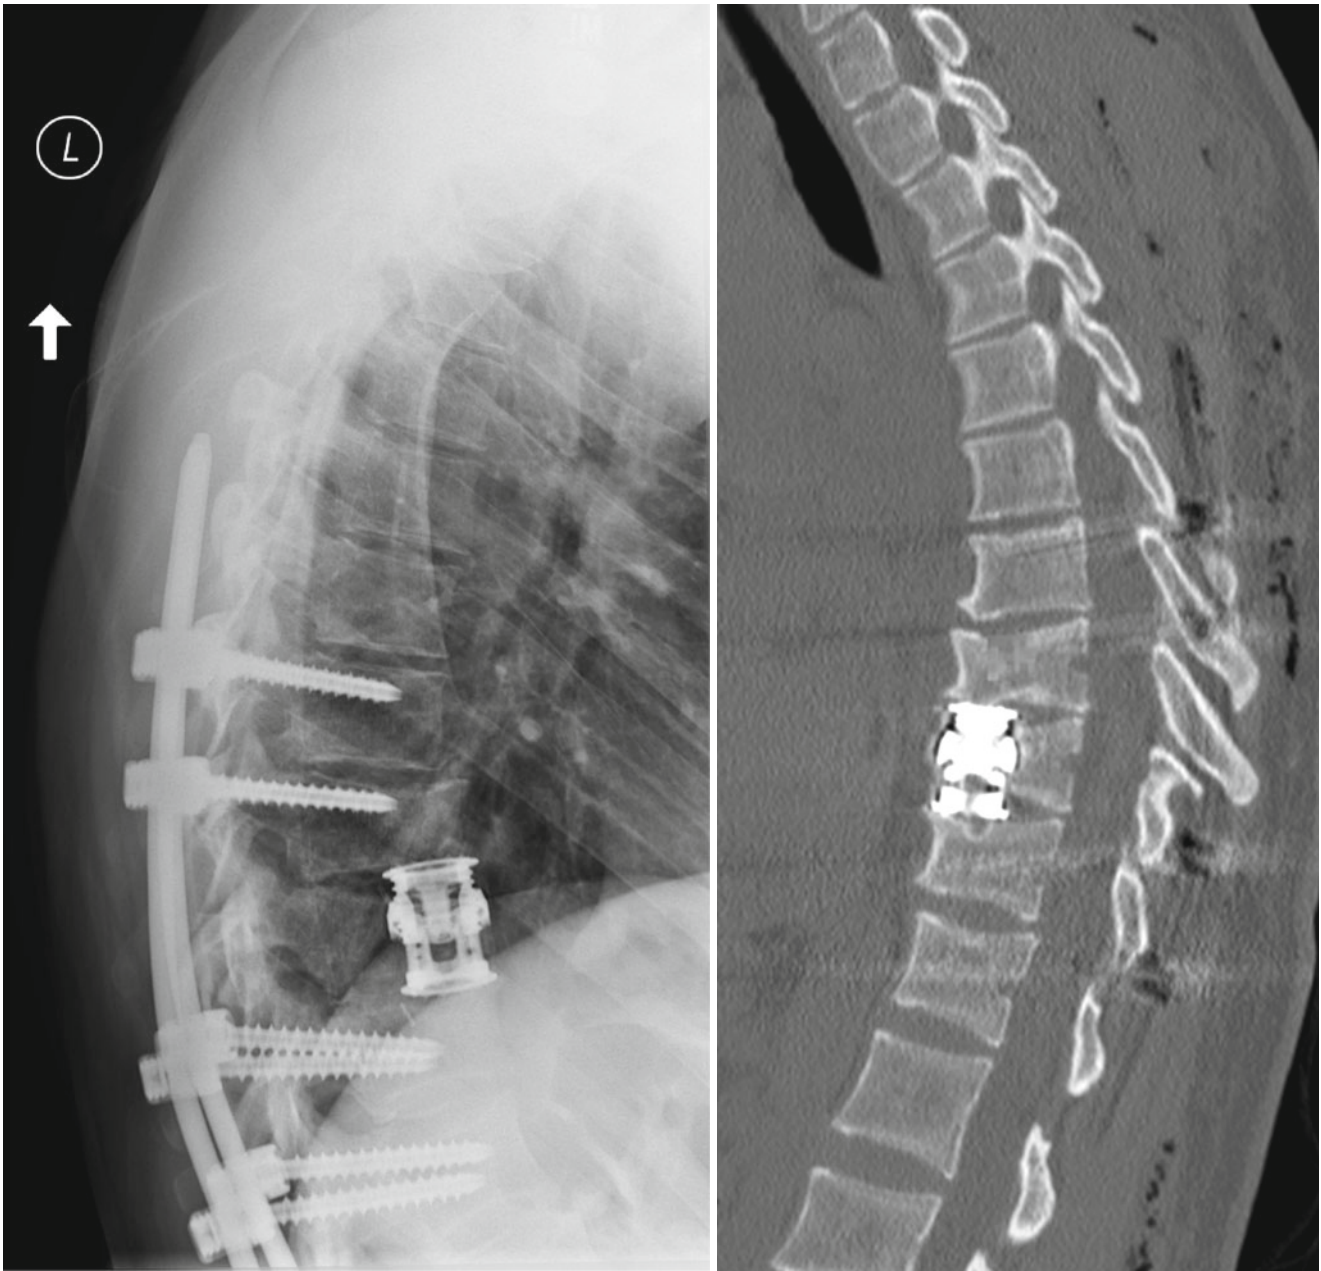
(Left) Postoperative lateral X-ray thoracic spine and (right) sagittal slice of the thoracic spine demonstrating thoracic corpectomy with interbody expandable cage
